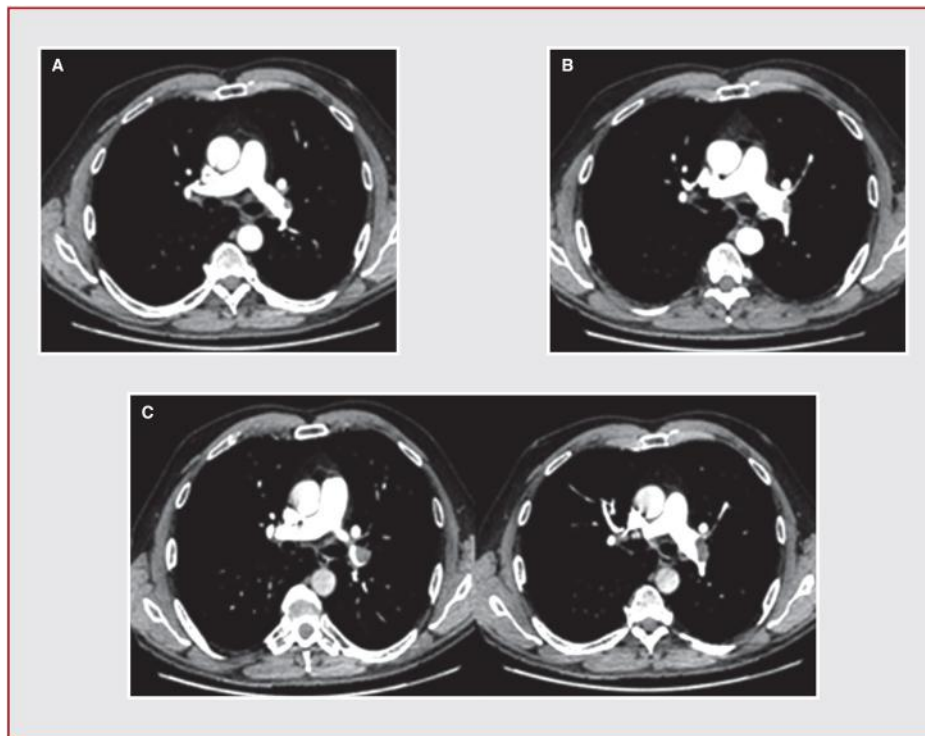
Not pulmonary embolism recurrence: tumour thrombi. Asymptomatic left-sided lobar pulmonary “embolism” diagnosed on a routine CT scan after resection of renal-cell carcinoma with venous invasion (A). After 6 months of anticoagulants, the endovascular “thrombus” looks larger (B). A new CT scan 3 months later confirms thrombus growth (C). Solitary endovascular metastasis of the renal carcinoma was confirmed pathologically by pulmonary endarterectomy.
